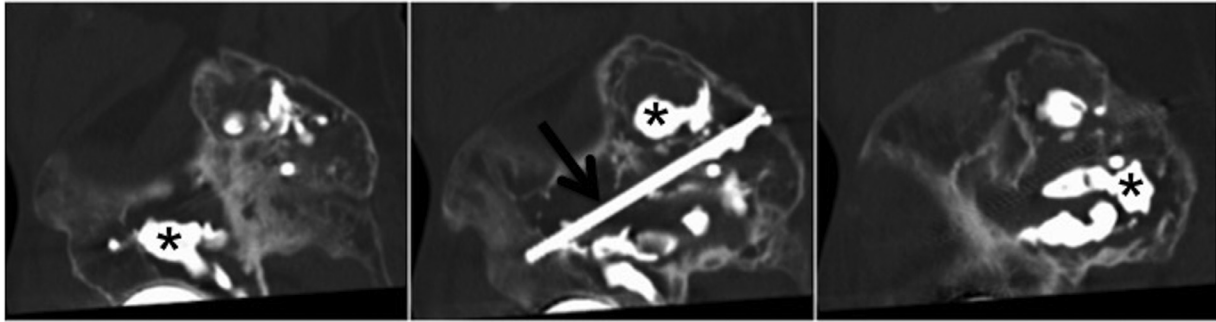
(Patient 2) Sagittal-oblique medial to lateral reformatted computed tomography series shows satisfactory bone cement (*) distribution throughout the lytic tumor cavity pockets and a 120 mm long x 6.5 mm wide screw (arrow) across the long axis of the mass, embedded in the residual acetabulum and the cortex.
